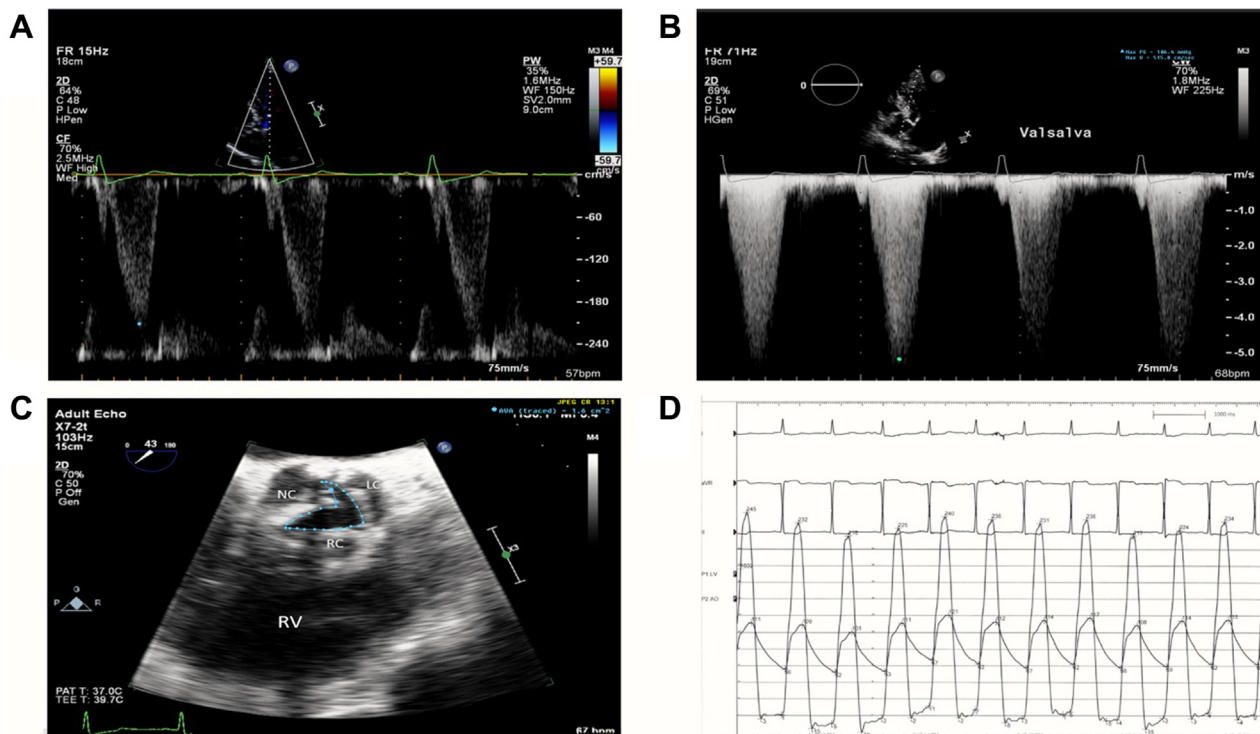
Case 1: two-dimensional TTE, apical five-chamber view, pulsed-wave Doppler (A) and CWD (B) spectral displays, demonstrates a maximal LVOT velocity of 2.1 m/s (18 mm Hg) and maximal late-peaking aortic velocity during Valsalva of 5.2 m/s (106 mm Hg), respectively. (C) Two-dimensional TEE, midesophageal short-axis (43°) systolic view, demonstrates mild AS with AVA of 1.6 cm² by planimetry. (D) Left heart catheterization pressure tracing from the LV apex and the aorta demonstrates an estimated peak-to-peak gradient of 120 mm Hg. LC, Left coronary cusp; NC, noncoronary cusp; RC, right coronary cusp
